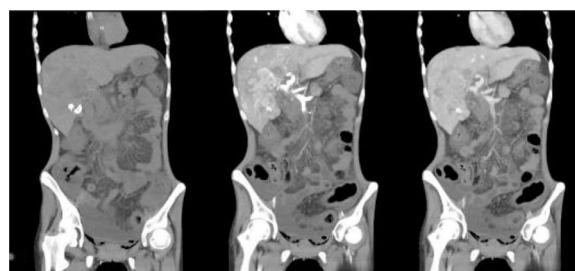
Triphasic abdominal CT scan. Liver, enlarged with multiple lesions located in segments V, VI, and VII, with defined borders, heterogeneous, with peripheral hypodense halo, hyperdense center in all phases, more pronounced in the arterial phase. Left branch of the portal vein, with filling defect attached to the wall, and right branch with decreased caliber.
